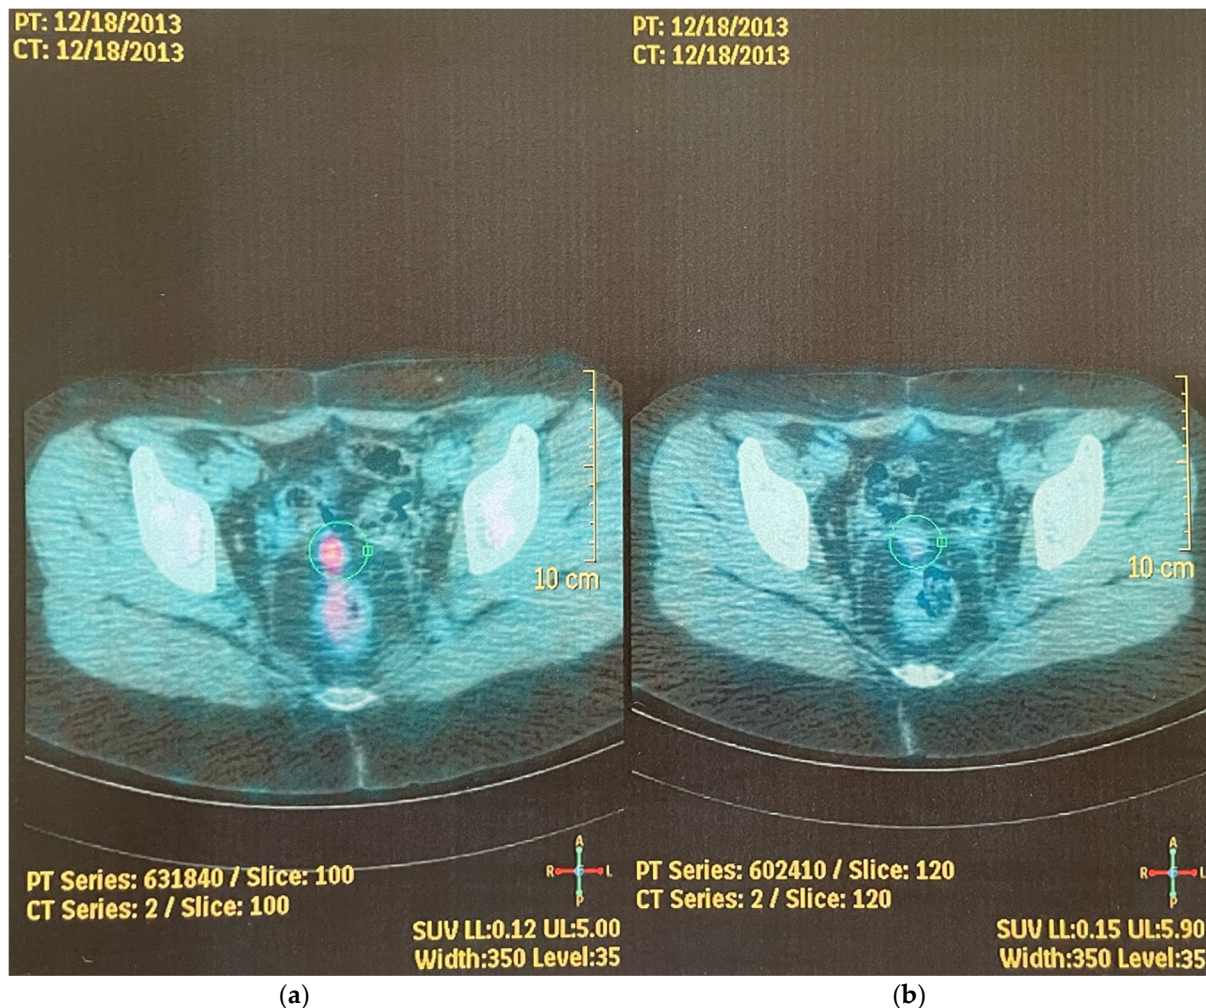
Positron emission tomography. The nodule shown in Figure 1 is further characterized through an FDG PET/TC scan. The middle density nodule found on the axial CT scan (b) is shown to be metabolically active (standardized uptake value of 3.7) on an FDG PET (a), suggesting the diagnosis of recurrence.
